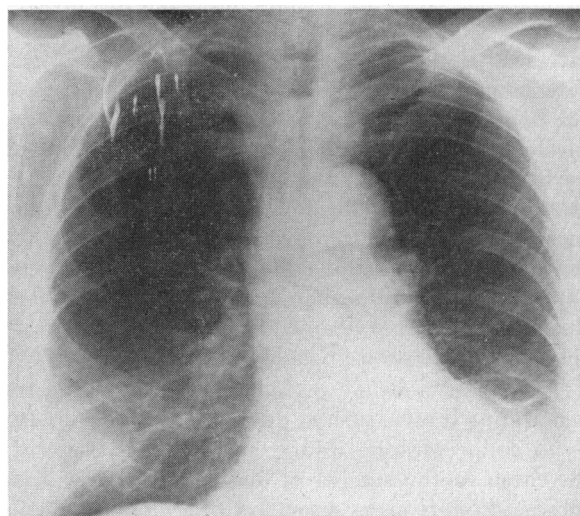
(Case 1).—X-ray film of chest following ligation of thoracic duct showing continued presence of a moderate amount of chyle.
